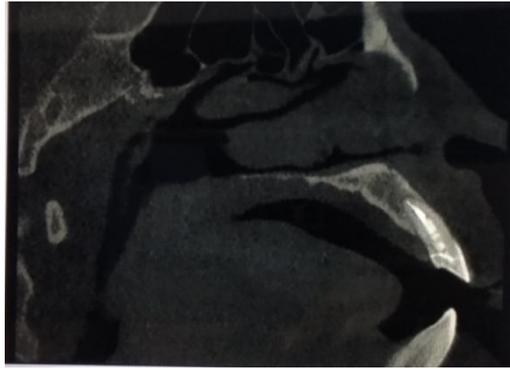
CBCT showing complete approximation of fractured segments with no bone loss either in the crestal or in the periapical area
